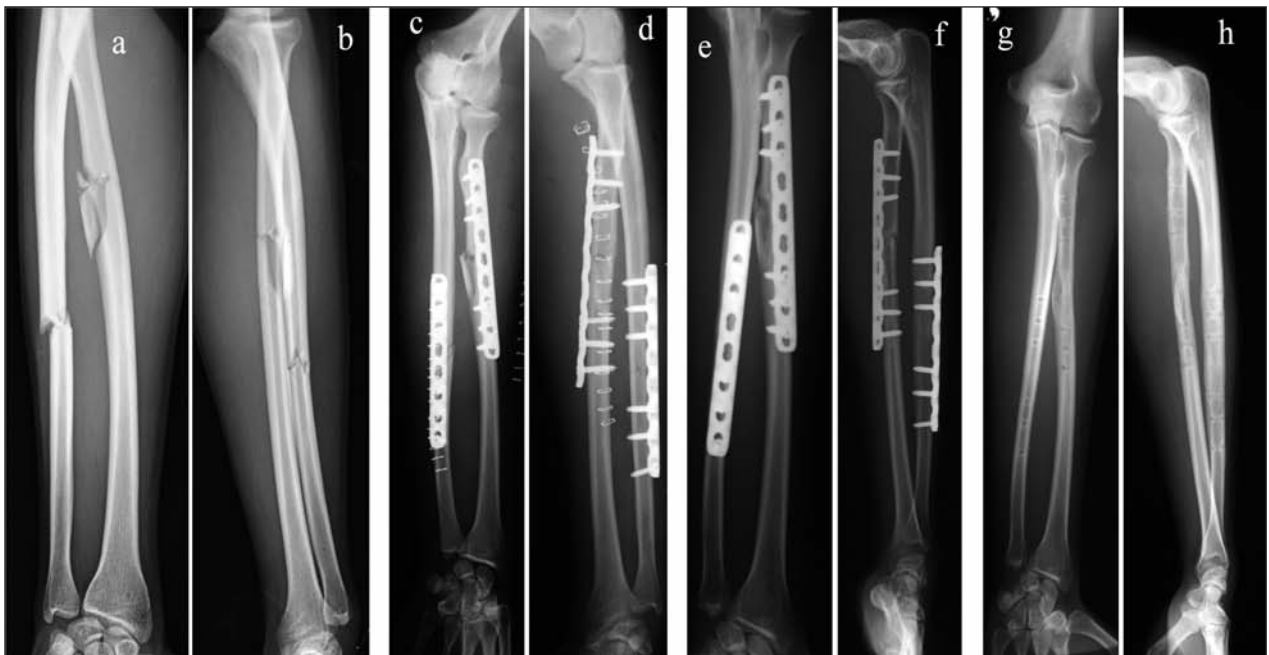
Case 27, male, aged 22: a-b) pre-operative X-ray; c-d) postoperative check-up; e-f) follow-up 4 months later; g-h) follow-up 18 months later.
